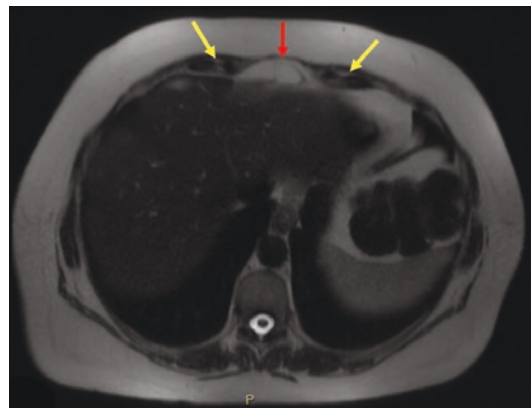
MR image performed in the T2 phase in the same patient displaying rectus diastasis (red arrow). The rectus muscles (yellow arrows) appear dark due to high water content
